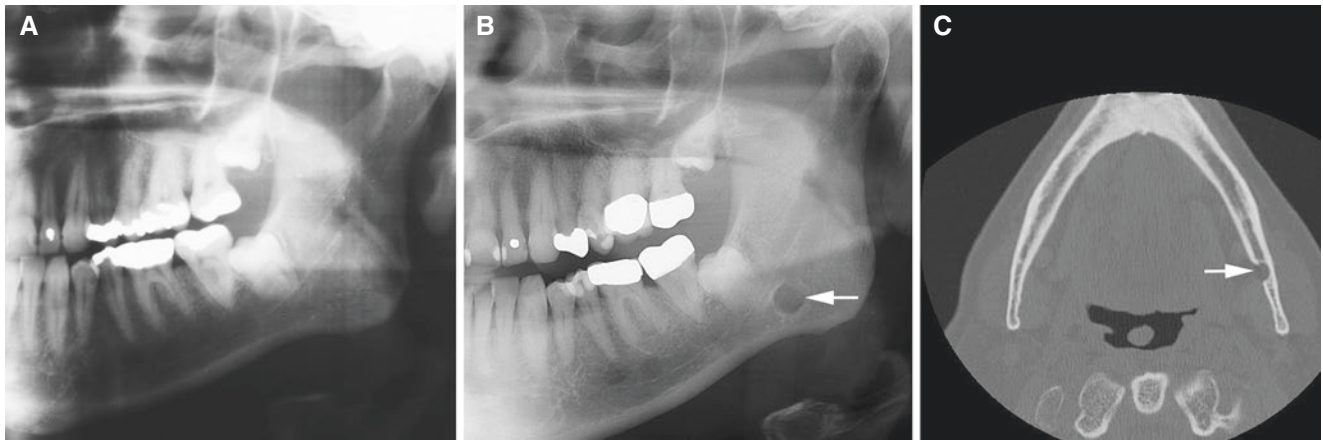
Stafne bone cyst, developed in adult age, incidental finding. (A) Panoramic view (28-year-old male) with normal bone in the left mandibular angular region. (B) Panoramic view and (C) axial CT image (patient now 65 years old) show cyst/defect (arrow)
